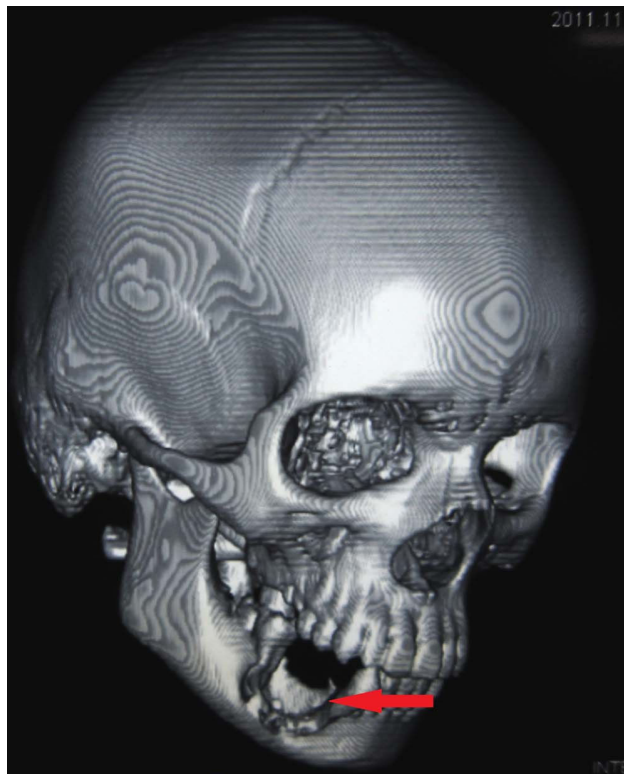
3D-CT scan section showing osteolytic lesion
